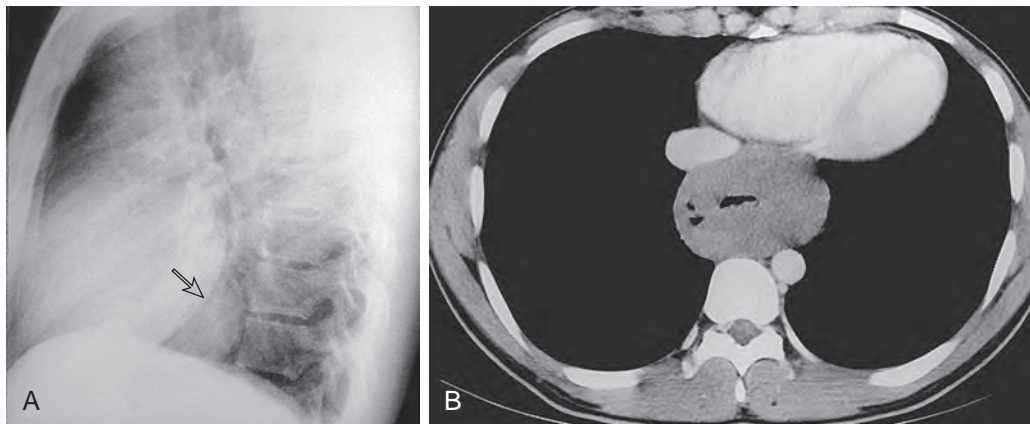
Esophageal leiomyoma. A. Lateral chest radiograph demonstrates a soft tissue mass (arrow) between the heart and the spine. B. CT scan shows the homogeneous mass encircling the distal esophagus. Tiny air collections in the mass resulted from prior biopsy.
